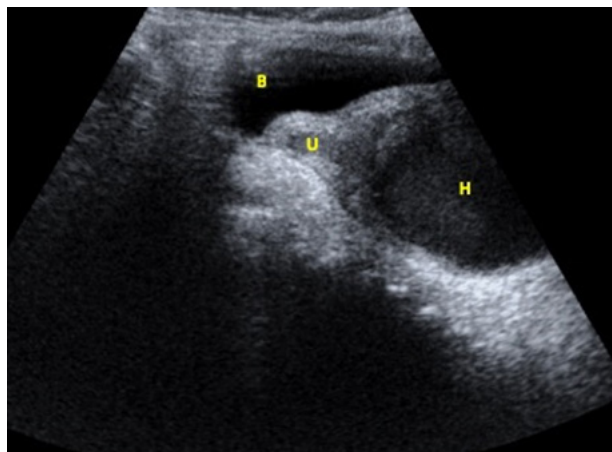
Pelvic ultrasound (longitudinal) showing the bladder (B), the left hemi-uterus (U) and a hematocolpos of heterogenous content in the obstructed hemi-vagina (H).
